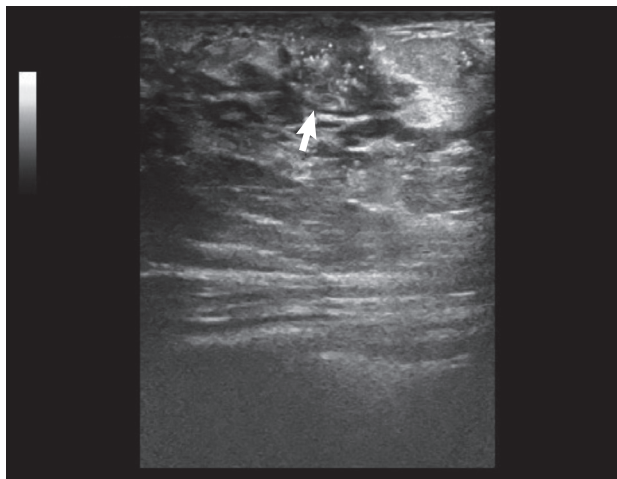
Ultrasonographic image of the breast lesion (arrow).
